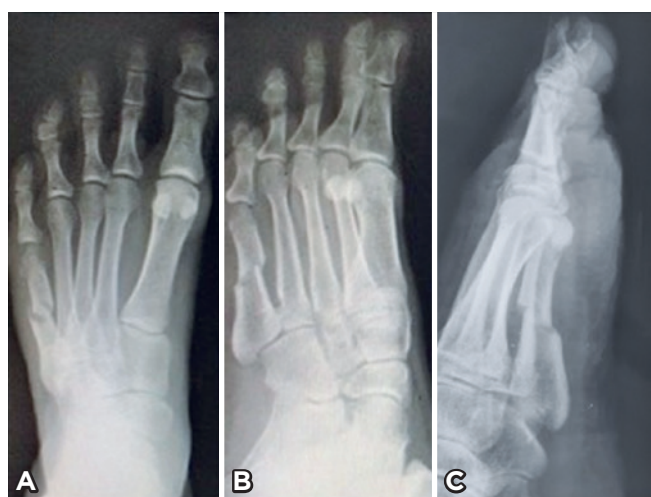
Radiograph obtained at postoperative week 6. A) Anteroposterior view. B) Oblique view. C) Lateral view, highlighting the obliquity of osteotomy and contact between fragments.
